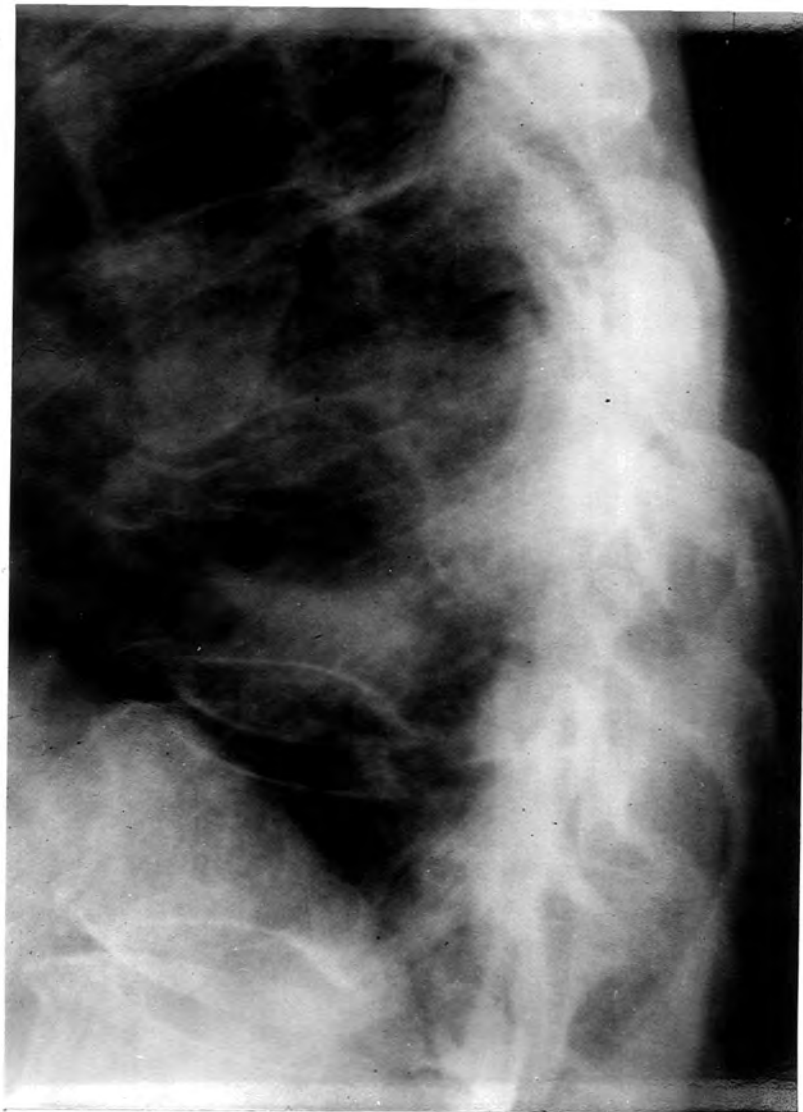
CASE TWENTY-TWO. X-ray of thoracic spine, lateral view. The body of T.8 has collapsed and is severely compressed.
